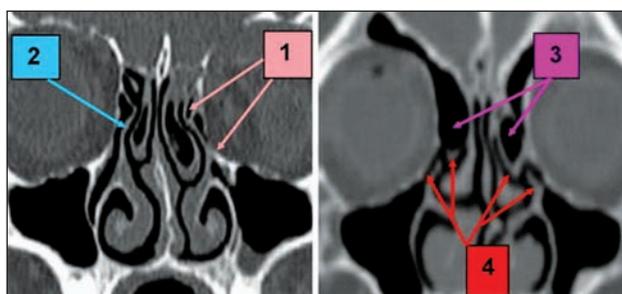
Paranasal sinuses CT scan, bone window, coronal slices: 1. superior insertion of the left uncinate process into the pneumatized superior turbinate and lamina papyracea; 2. superior insertion on the right uncinate process into the lamina papyracea; 3. bilateral pneumatization of the superior turbinate; 4. bilateral superior insertion of the uncinate process into the pneumatized superior turbinate and lamina papyracea
